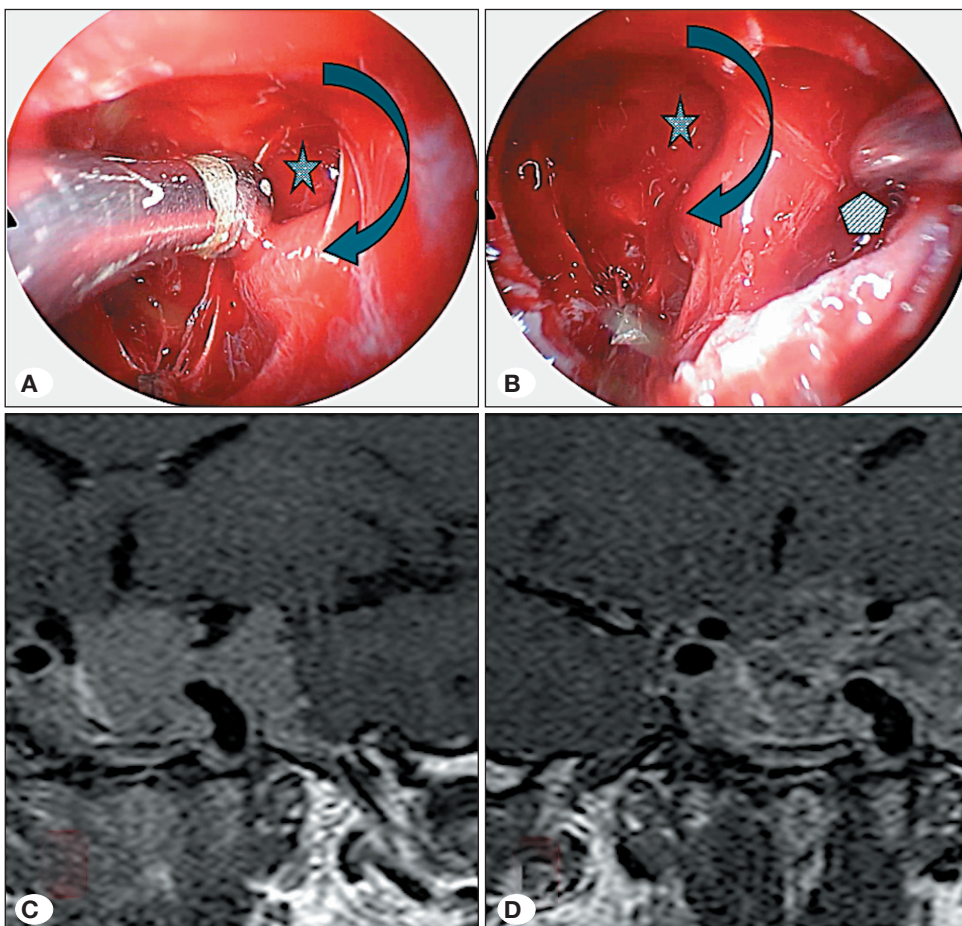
Tumor extension and surgical approaches. In the present case, the tumor extends into the superior and lateral compartments. A) The anterior and horizontal segments of the cavernous segment of the internal carotid artery are exposed. Entry is achieved via the medial corridor (marked with a star), allowing access to the tumor located in the superior compartment using an aspirator. B) Surgical dissection proceeds laterally to the cavernous segment of the internal carotid artery, and the tumor tissue within the lateral compartment (marked with a pentagon) is accessed and excised. C,D) Pre- and postoperative magnetic resonance imaging findings.
